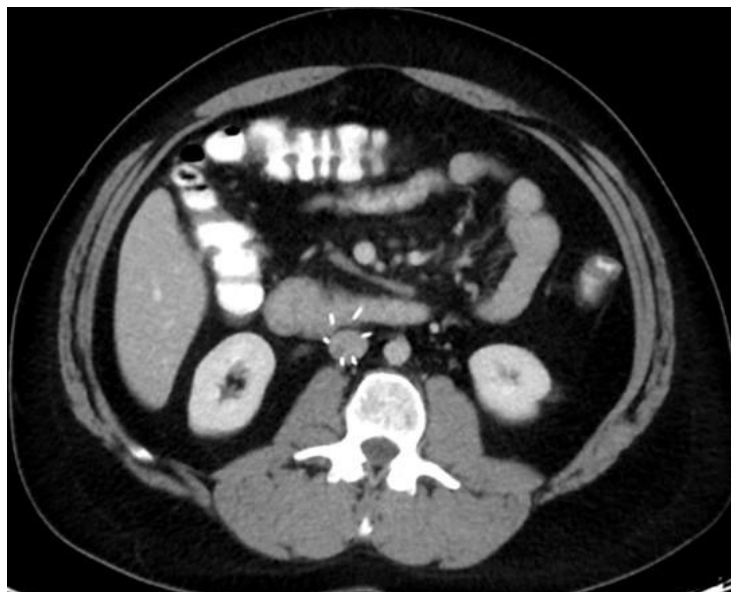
CT abdomen axial view showing IVC filter struts perforating into the proximal third part of the duodenum.
